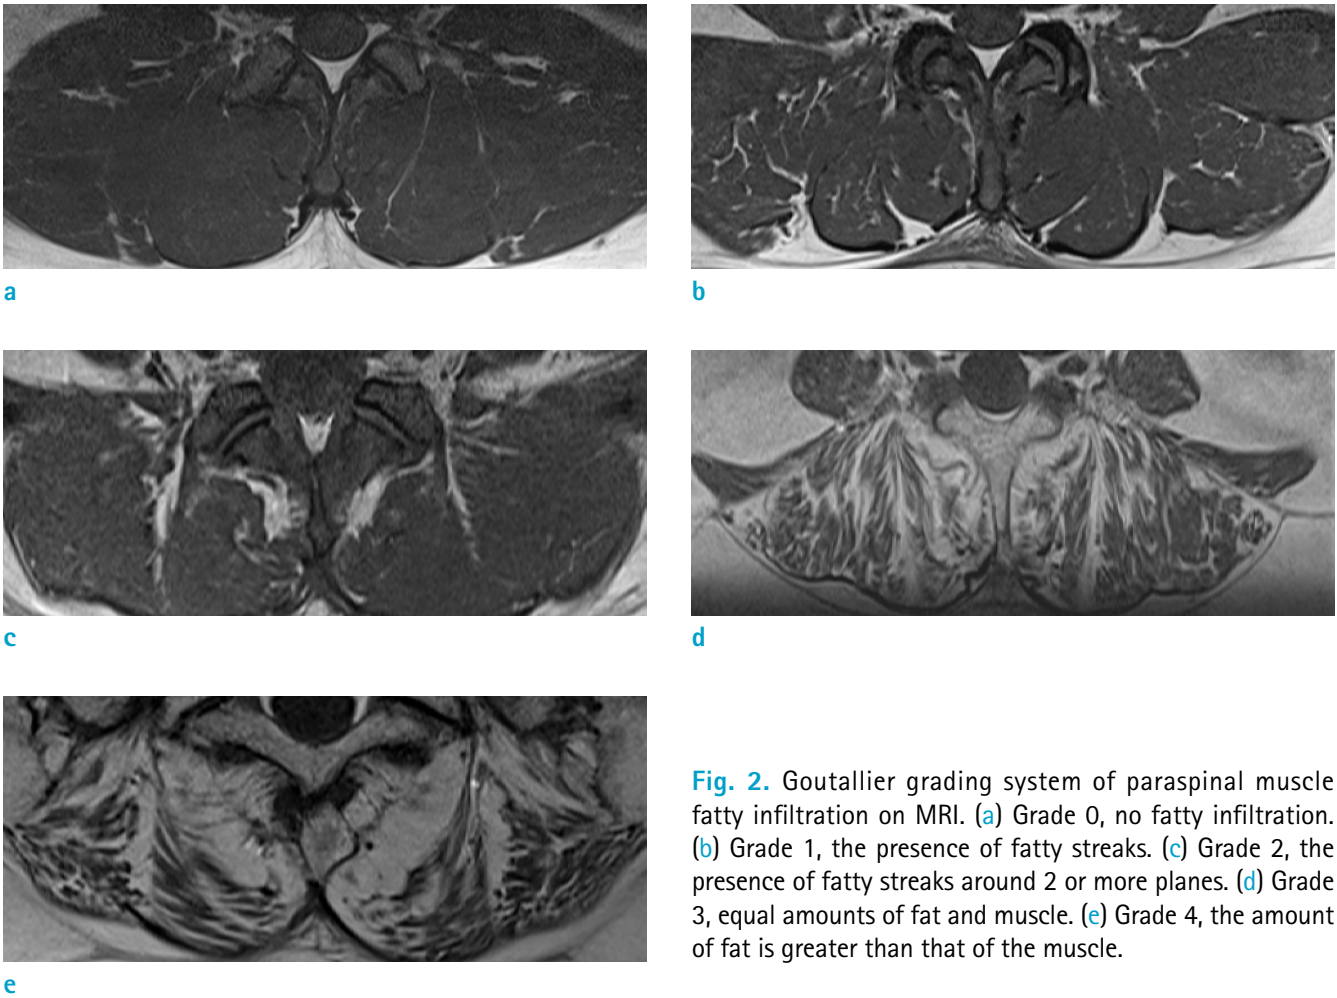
Goutallier grading system of paraspinal muscle fatty infiltration on MRI. (a) Grade 0, no fatty infiltration. (b) Grade 1, the presence of fatty streaks. (c) Grade 2, the presence of fatty streaks around 2 or more planes. (d) Grade 3, equal amounts of fat and muscle. (e) Grade 4, the amount of fat is greater than that of the muscle.
